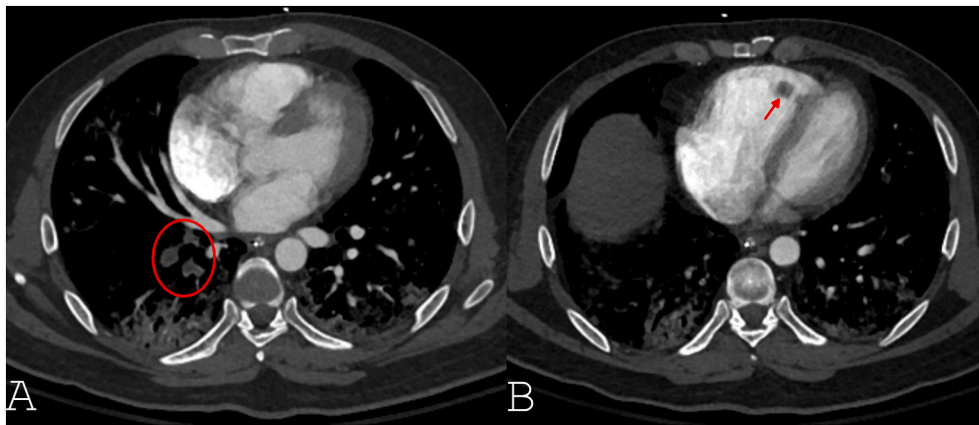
Axial CT angiography of the chest. A) Multiple filling defects in the right lower lobe subsegmental pulmonary arteries (circle) consistent with pulmonary thromboembolism. B) Right ventricular mass (arrow) suspicious for intracardiac thrombus.
